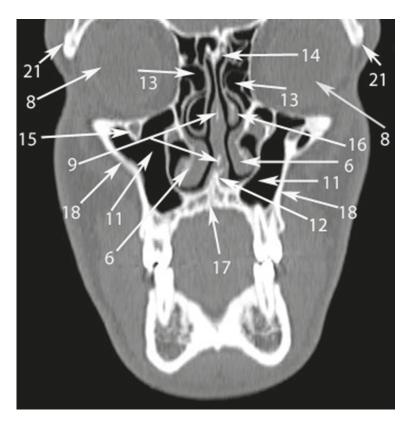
Coronal CT scan at the level of 1st premolars. *Numbers* with *arrows* denote the following anatomical structures: 6 – inferior nasal concha; 8 – orbit; 9 – perpendicular plate of the ethmoid bone; 11 – maxillary sinus; 12 – vomer; 13 – ethmoidal air cells (Latin: cellulae ethmoidalis); 14 – nasal spine of the frontal bone; 15 – infraorbital canal; 16 – middle nasal concha; 17 – hard palate (palatine process of the maxilla); 18 – the outer cortical plate of the maxilla; 21 – zygomatic process of the frontal bone.
